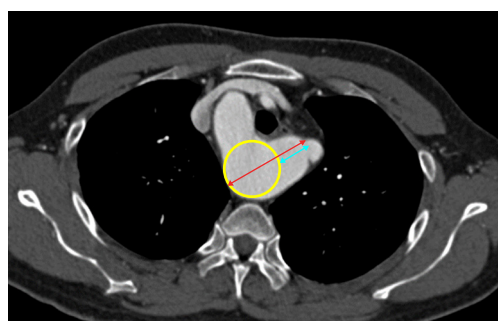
The measurement sites of the KD are shown in the computed tomographic image. The DAW is indicated by the red double-headed arrow. The height of KD is indicated by the blue double-headed arrow. The yellow circle indicates the estimated native aortic diameter. DAW, distance to the opposite aortic wall; KD, Kommerell diverticulum.
